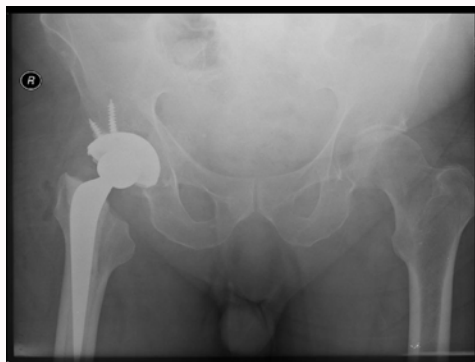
Pelvic radiograph showing a hybrid Right Total Hip Replacement (THR).
